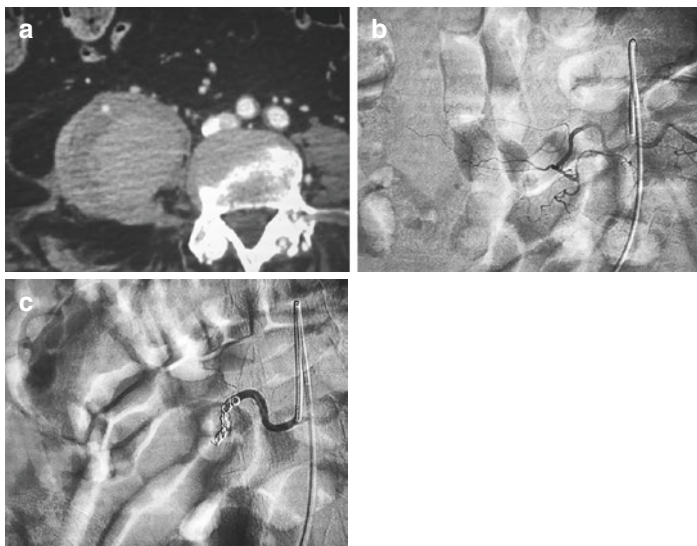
(a) Contrast-enhanced CT in a patient with SARS-CoV-2 infection who developed large hematoma of the right psoas muscle with focal spreading of contrast medium (b) angiogram during the angioembolization procedure showing the active bleeding. (c) Final control after metallic coils positioning
